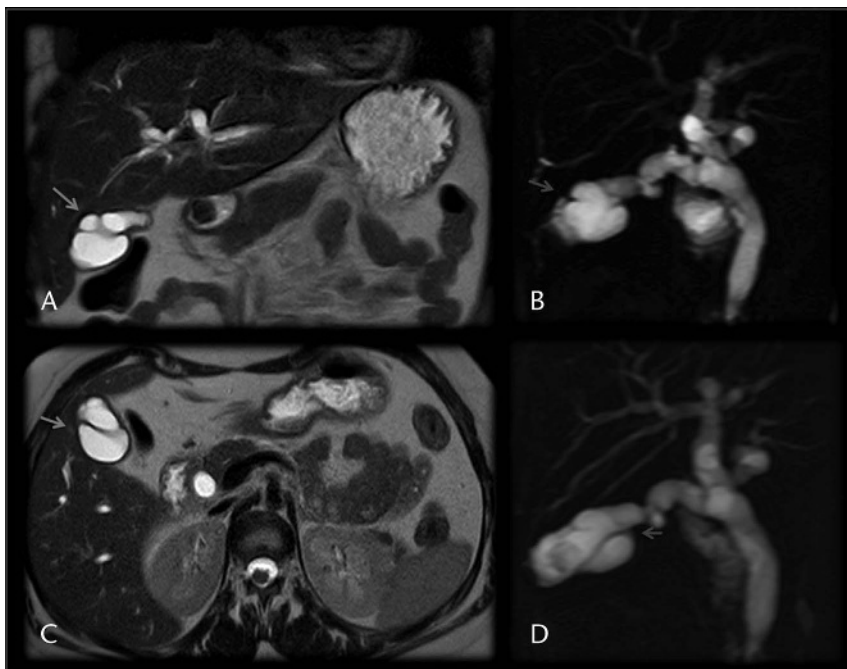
Magnetic resonance imaging cholangiogram depicting partial septate gallbladder. The sequences show multiple incomplete septa, which are connected to each other. Partial septa are best evaluated in cholangiography sequences B–D. A, T2 hASTE cor. C, T2 hASTE ax. B and D, Cholangiography 3-dimensional sequence.
